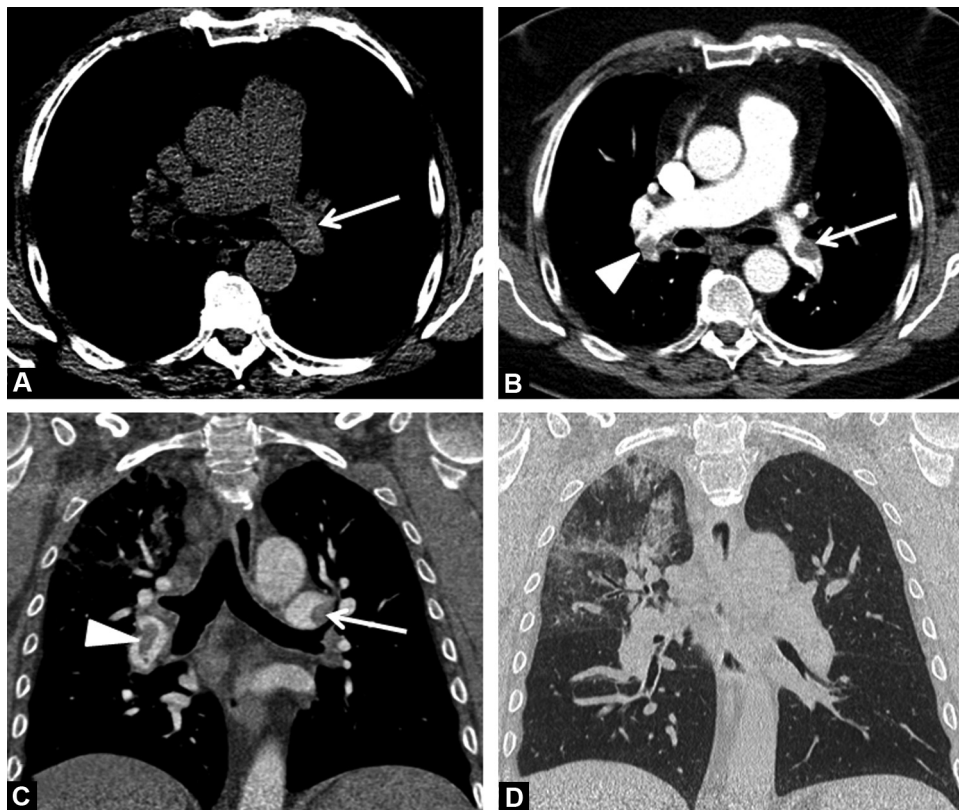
60-year-old man with COVID-19 pneumonia and acute pulmonary embolism. A. Unenhanced CT image in the axial plane (mediastinal window: W 410/L 10 HU) shows spontaneously hyperattenuating clot (arrow) in the left main pulmonary artery. B. CT image in the axial plane (mediastinal window: W 410/L 10 HU) obtained after intravenous administration of iodinated contrast material confirms thrombus in the left main pulmonary artery (arrow) and reveals contralateral thrombus in the right interlobar artery (arrowhead). C. CT image in the coronal plane (mediastinal window: W 410/L 10 HU) depicts filling defects in the left main pulmonary artery (arrow) and right interlobar artery (arrowhead). D. CT image in the coronal plane (lung window: W 1600/L–500 HU) shows diffuse involvement of upper right lobe by ground-glass opacities, interlobular septal thickening, peribronchovascular consolidations and perihilar bronchial wall thickening.
